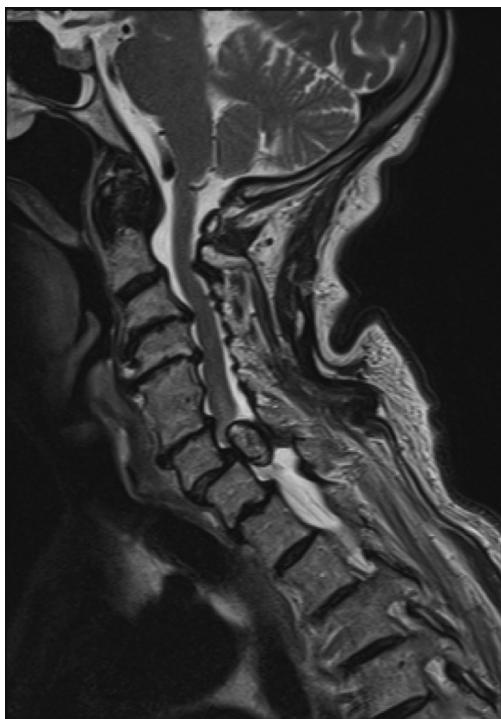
(Left) Sagittal T2-weighted magnetic resonance image of the likely intradural mass causing compression on the spinal cord at the C7–T1 levels. (Right) Axial T2-weighted magnetic resonance image of the mass with compression of the spinal cord.
